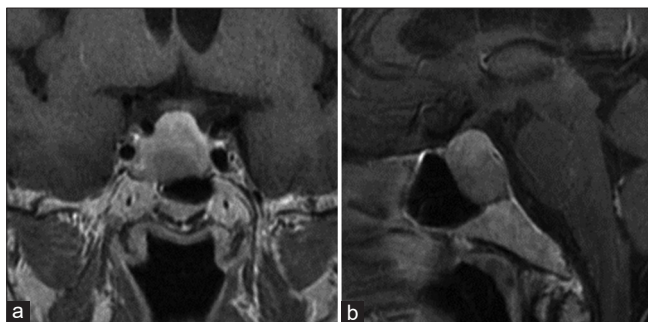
(a) Magnetic resonance imaging (MRI) coronal section preoperative brain MRI reveals a macro pituitary neuroendocrine tumor (PitNET) (30 × 27 × 25 mm). (b) MRI sagittal section preoperative brain MRI reveals a macro PitNET (30 × 27 × 25 mm).
